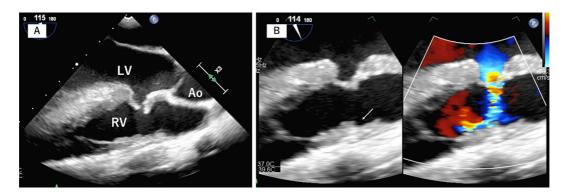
Transesophageal echocardiography with Doppler demonstrating perimembranous VSD (A) with vegetation (arrow) in the free wall of the right ventricle where the jet from the VSD impacts (B). Ao: aorta, LV: left ventricle, RV: right ventricle
